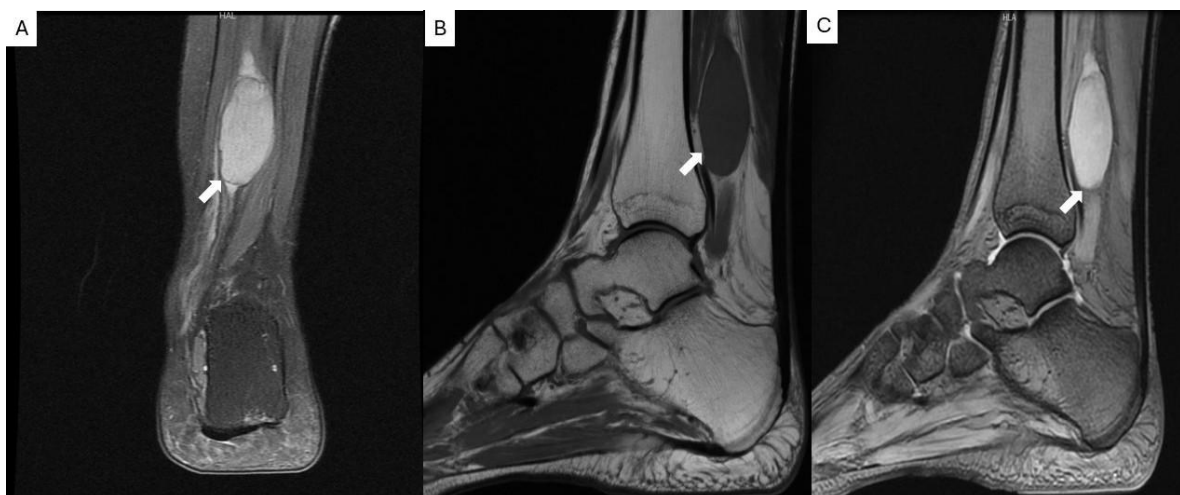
Magnetic resonance imaging of the left ankle showing a posterior tibial nerve schwannoma. (A) Coronal proton density-weighted fat-suppressed image demonstrates a well-circumscribed, fusiform, hyperintense mass along the course of the posterior tibial nerve (arrow). (B) Sagittal T1-weighted image shows the lesion as homogeneously hypointense relative to the surrounding fat, with sharply defined margins (arrow). (C) Sagittal T2-weighted image demonstrates marked hyperintensity of the lesion (arrow). The mass measured approximately 19 × 19 × 46 mm and produced mild anterior displacement of the flexor hallucis longus myotendinous unit. The imaging characteristics and relationship to the posterior tibial nerve were consistent with a peripheral nerve sheath tumor, favoring schwannoma.
